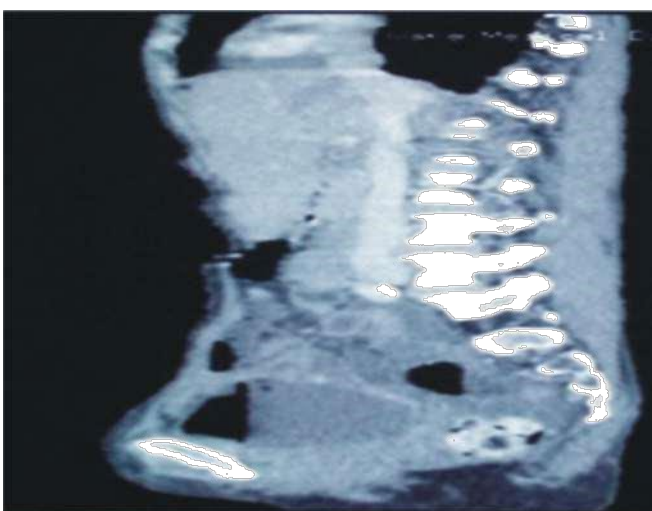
Abdominopelvic CT Scan showing air in the bladder with thickening of superior bladder wall and contiguous bowel wall.
